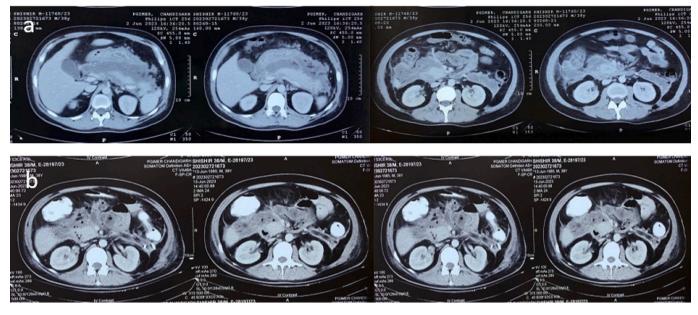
a)Pre operative CT images of patient underwent VARD. b) Postoperative CT images of the same patient with remnant deep seated necrosum in the pancreatic head region.
